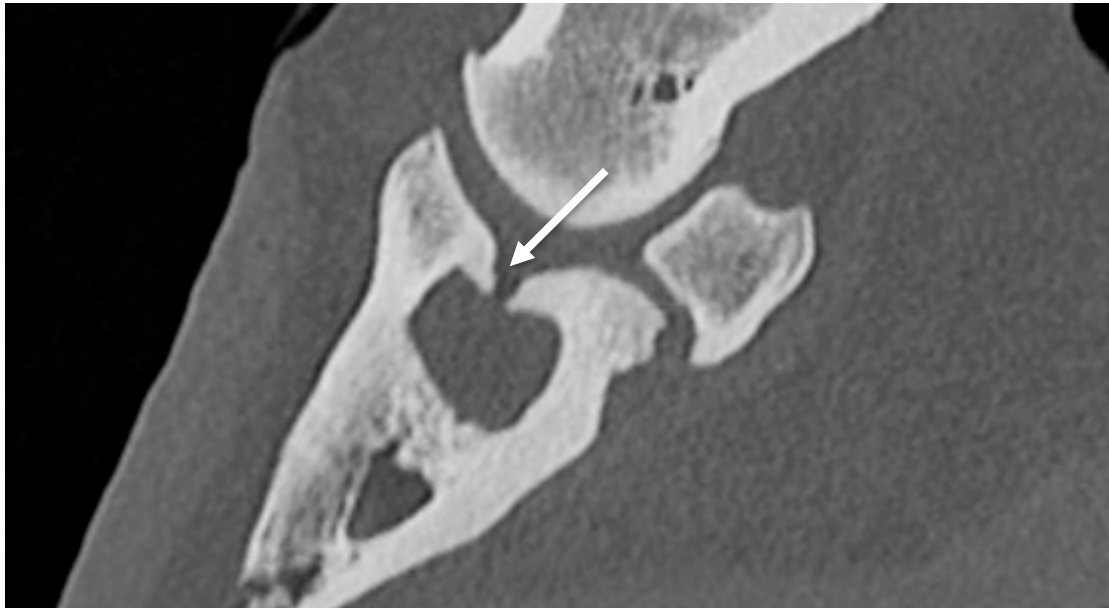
CT view of the same SCL in the sagittal plane, confirming the round shape and the neck-like communication with the joint (arrow).
